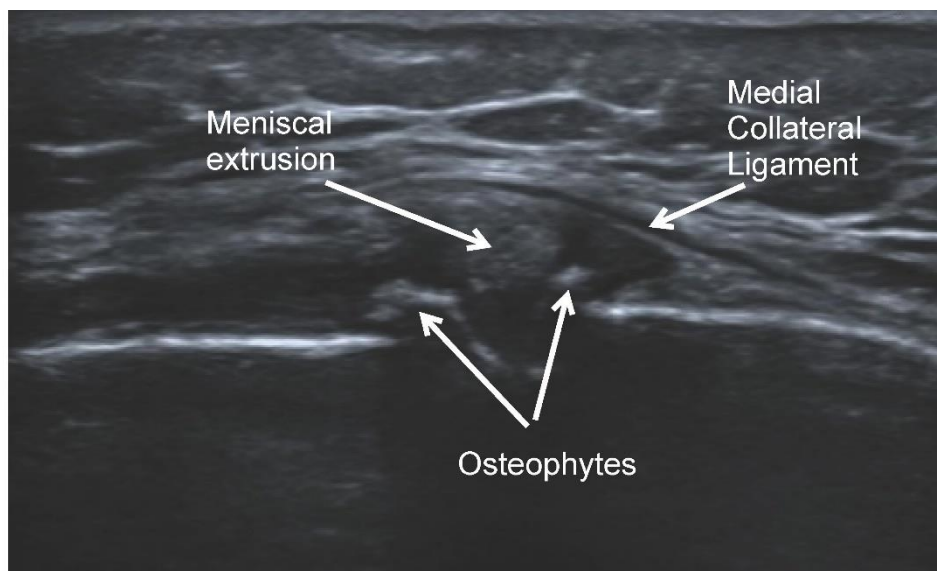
Longitudinal ultrasound image at the medial joint line of the knee demonstrating osteophytes and medial meniscal extrusion in a patient with osteoarthritis.
